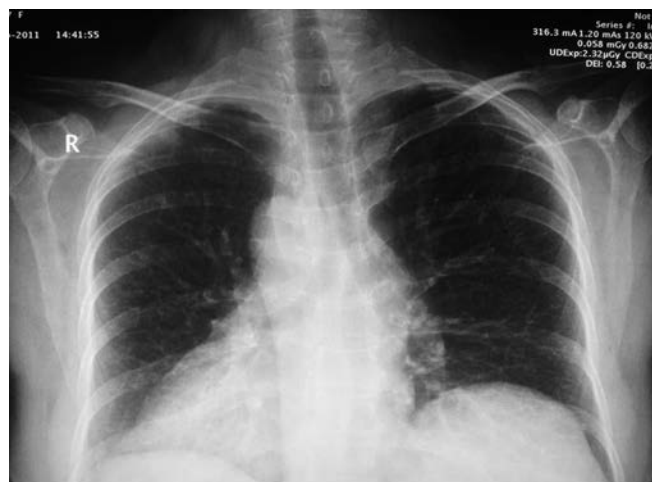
Case 1: Chest radiograph showing dextrocardia.
